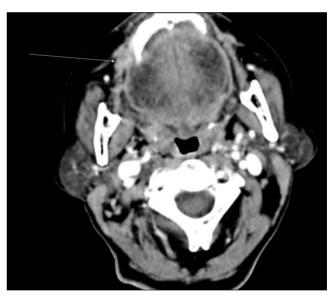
Axial contrast-enhanced CT showing right buccal tumour (white arrow).
